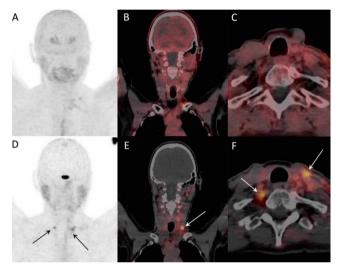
Head-to-head comparison between ¹⁸ F-DOPA (upper panel) and ⁶⁸Ga-DOTATOC (lower panel) PET/CT in a 45-years-old woman with metastatic sporadic MTC and previous history of thyroidectomy and lymph node dissection (central and left compartments, N+: 22/43). Serum calcitonin (400 ng/L, N < 10) was disproportionately increased than CEA (6 ng/mL, N < 5). ⁶⁸Ga-DOTATOC PET/CT revealed cervical nodal relapse (arrows) missed by ¹⁸ F-DOPA PET/CT. A, D: PET anterior maximum intensity projection (MIP); B, E: coronal PET/CT; C, F: axial PET/CT.
